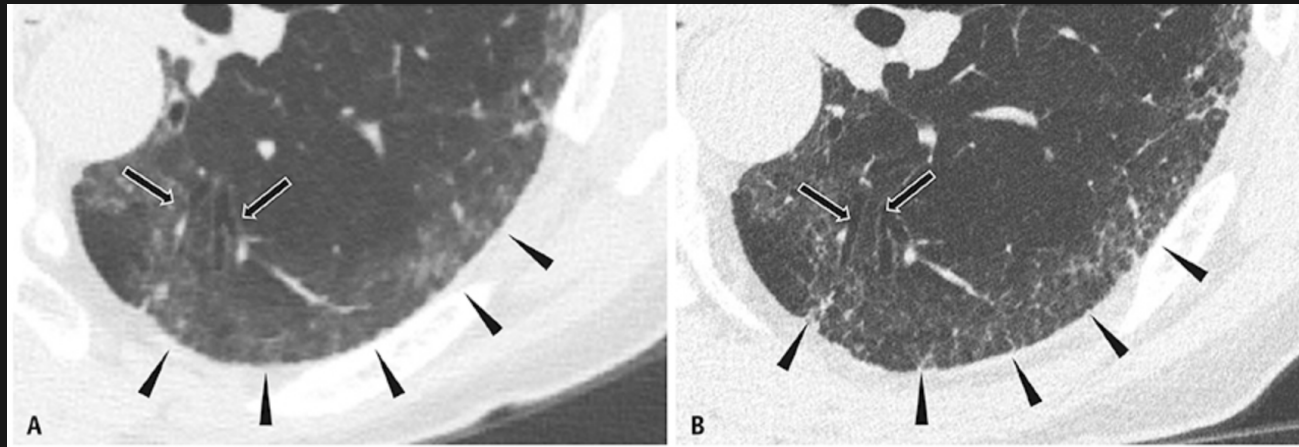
Idiopathic non-specific interstitial pneumonia was scanned on conventional energy-integrating detector CT (A) and investigational PCD-CT (B). A, B. PCD-CT demonstrates fine reticulations (arrowheads, B) in the right subpleural right lower lobe, compared to conventional CT, which appears to show ground glass opacities in this region (arrowheads, A). PCD-CT more sharply displays traction bronchiectasis than conventional CT (arrows). [8]
